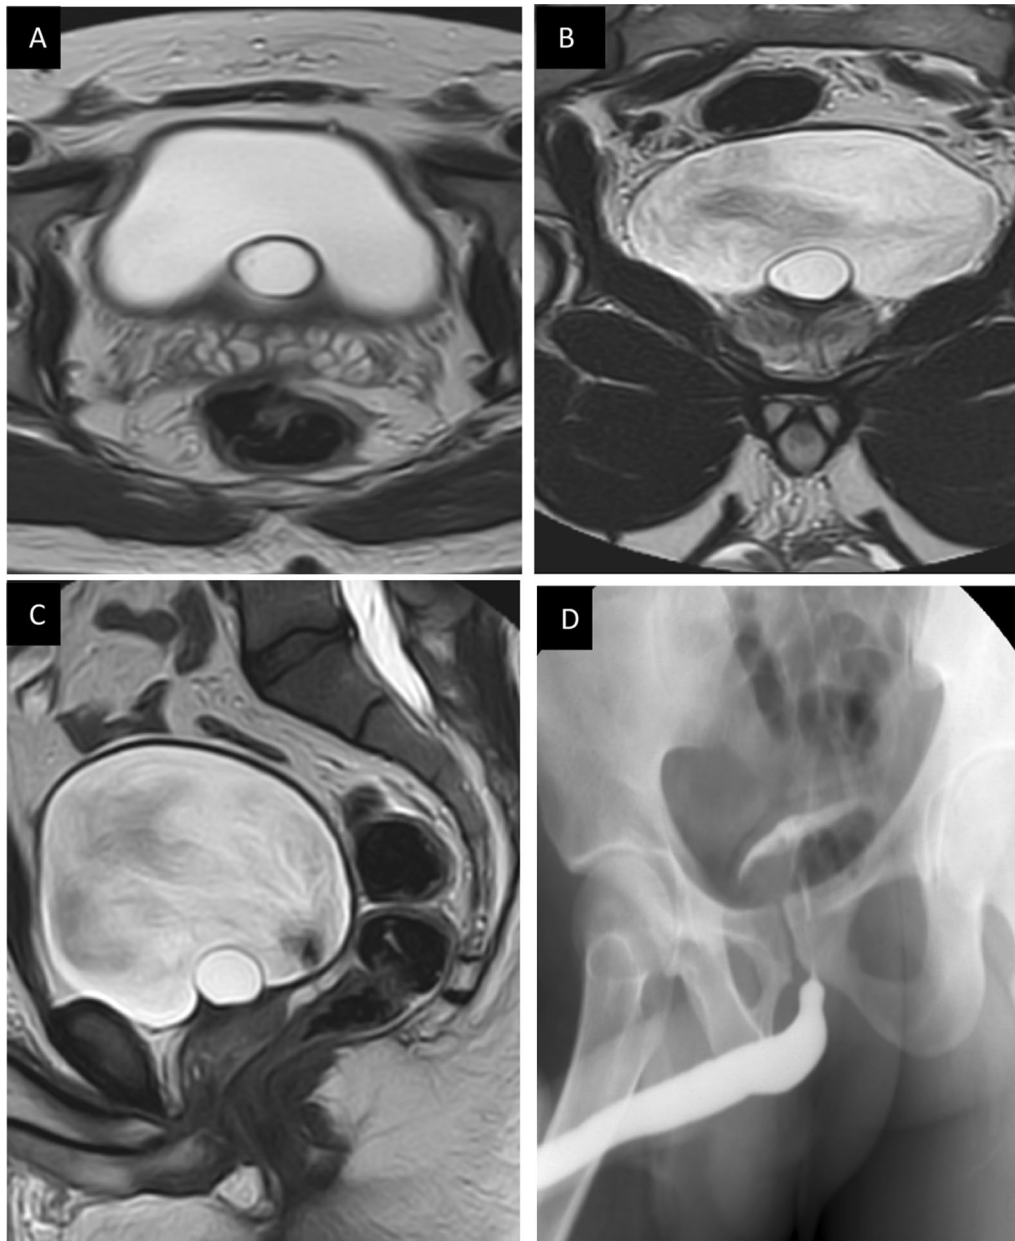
3 T. MRI of the pelvis: axial (A), coronal (B), and sagittal (C). High-resolution T2W images showing an anteriorly positioned midline prostatic cyst measuring (1.4 × 1.1 cm) projecting at the bladder base and neck, (D) conventional retrograde ascending urethrogram showing normal contrast opacification of the whole urethra with non filling or opaciing of the cyst confirming the non communication with the urethra
